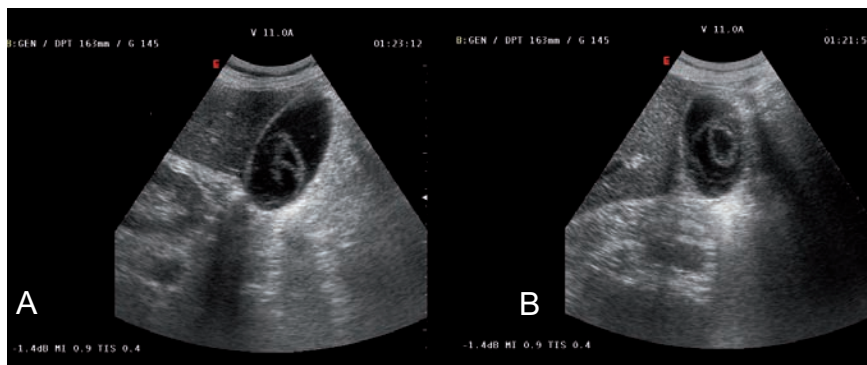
Ultrasonography of the abdomen showing echogenic, tubular, coiling lines inside the lumen of the gallbladder (A) with characteristic erratic, non-directional, zigzag movements (B).
